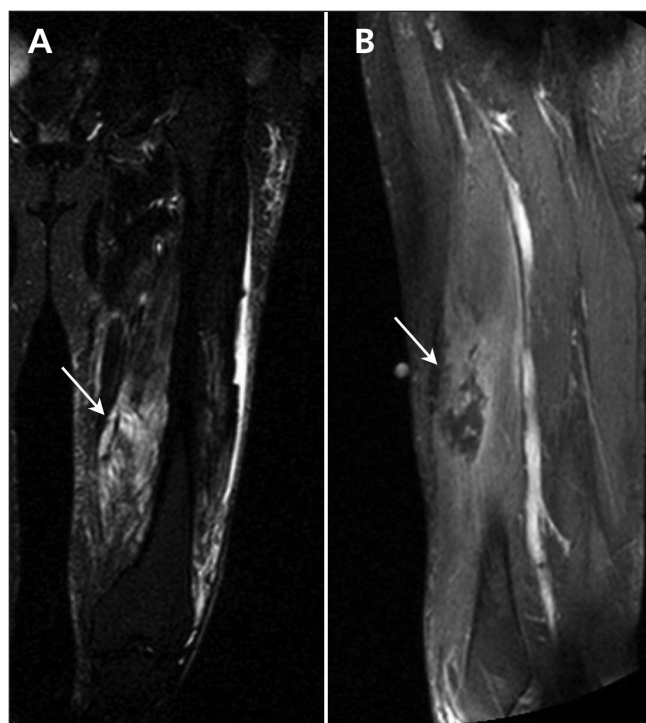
Magnetic resonance imaging of the patient's thigh. A: Coronal image showing diffuse, heterogeneous, intense signal of the involved muscle (arrow), which suggests edema. B: Sagittal image showing a heterogeneously enhanced mass (arrow) with peripheral enhancement after administration of gadolinium.
